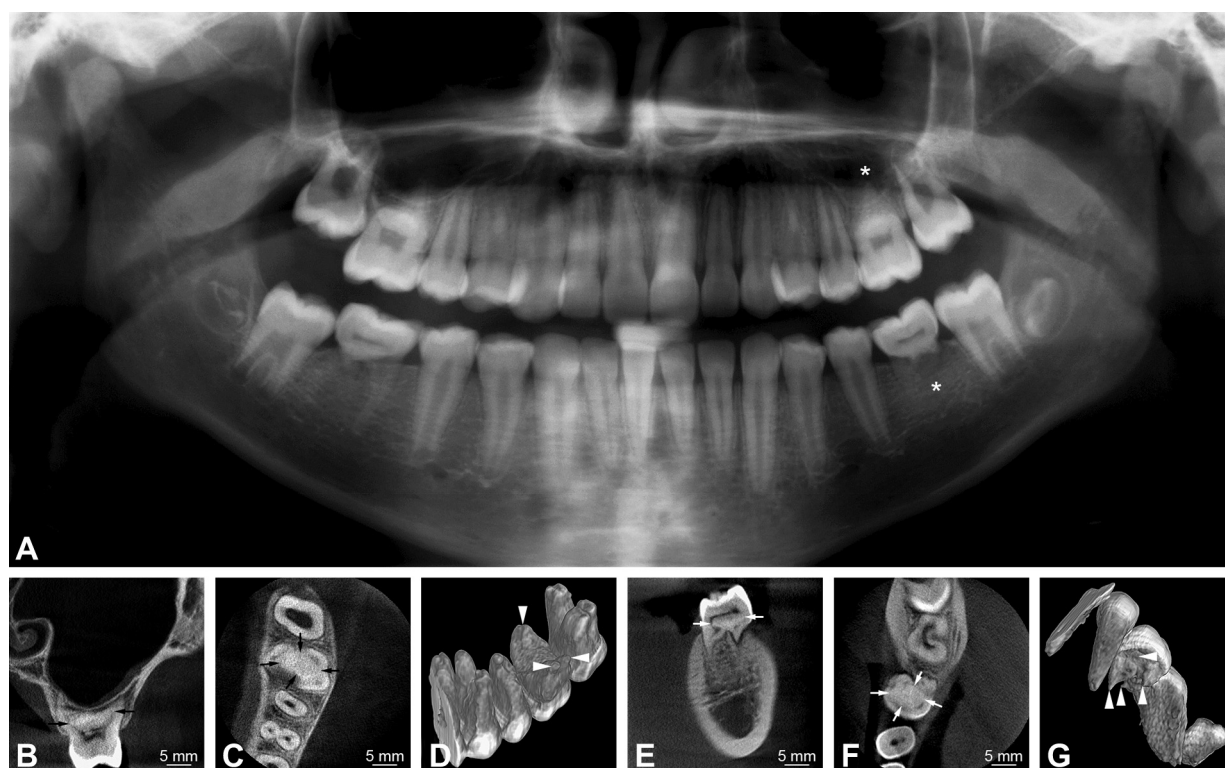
Radiographic appearance of the permanent first molars of patient 2. (A), Panoramic radiograph taken at the age of 10 years 6 months [asterisks mark the permanent upper and lower left first molars, which are shown in detail in (B)-(D) and (E)-(G), respectively]. (B)-(D), Bucco-lingual (B) and horizontal (C) CBCT sections and mesio-bucco-apical view of CBCT reconstruction (D) of the permanent upper left first molar. (E)-(G), Bucco-lingual (E) and horizontal (F) CBCT sections and mesio-bucco-apical view of CBCT reconstruction (G) of the permanent lower left first molar. Arrows in (B), (C), (E), and (F) point at the edges of the CMD, arrow-heads in (D) and (G) mark the root tips.
